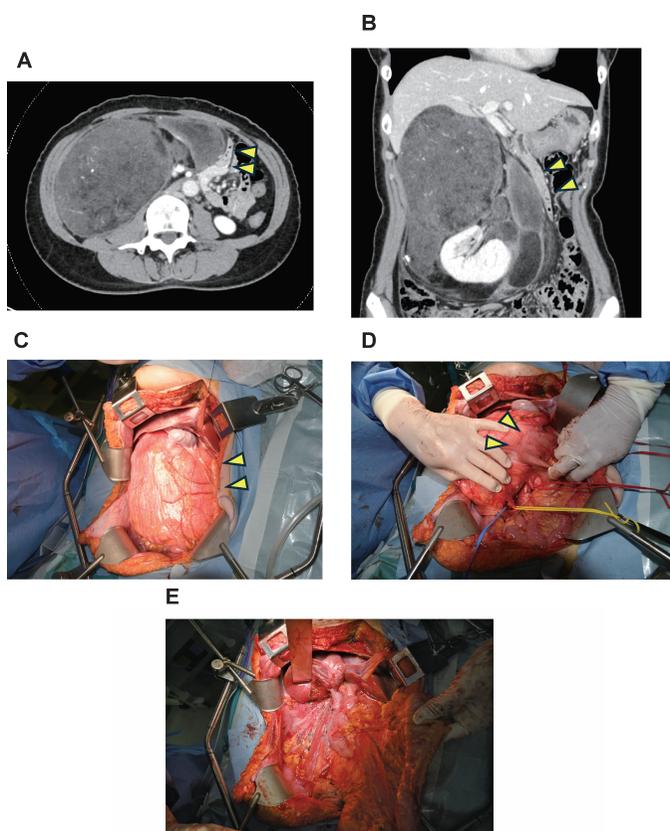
A case of a large right-sided retroperitoneal liposarcoma. Axial (A) and coronal (B) computed tomography images indicate that the tumor was in wide contact with the duodenum (arrowheads). There was no invasion of the tumor into the duodenum, and it was separated from the tumor (C and D). After tumor removal (E).
